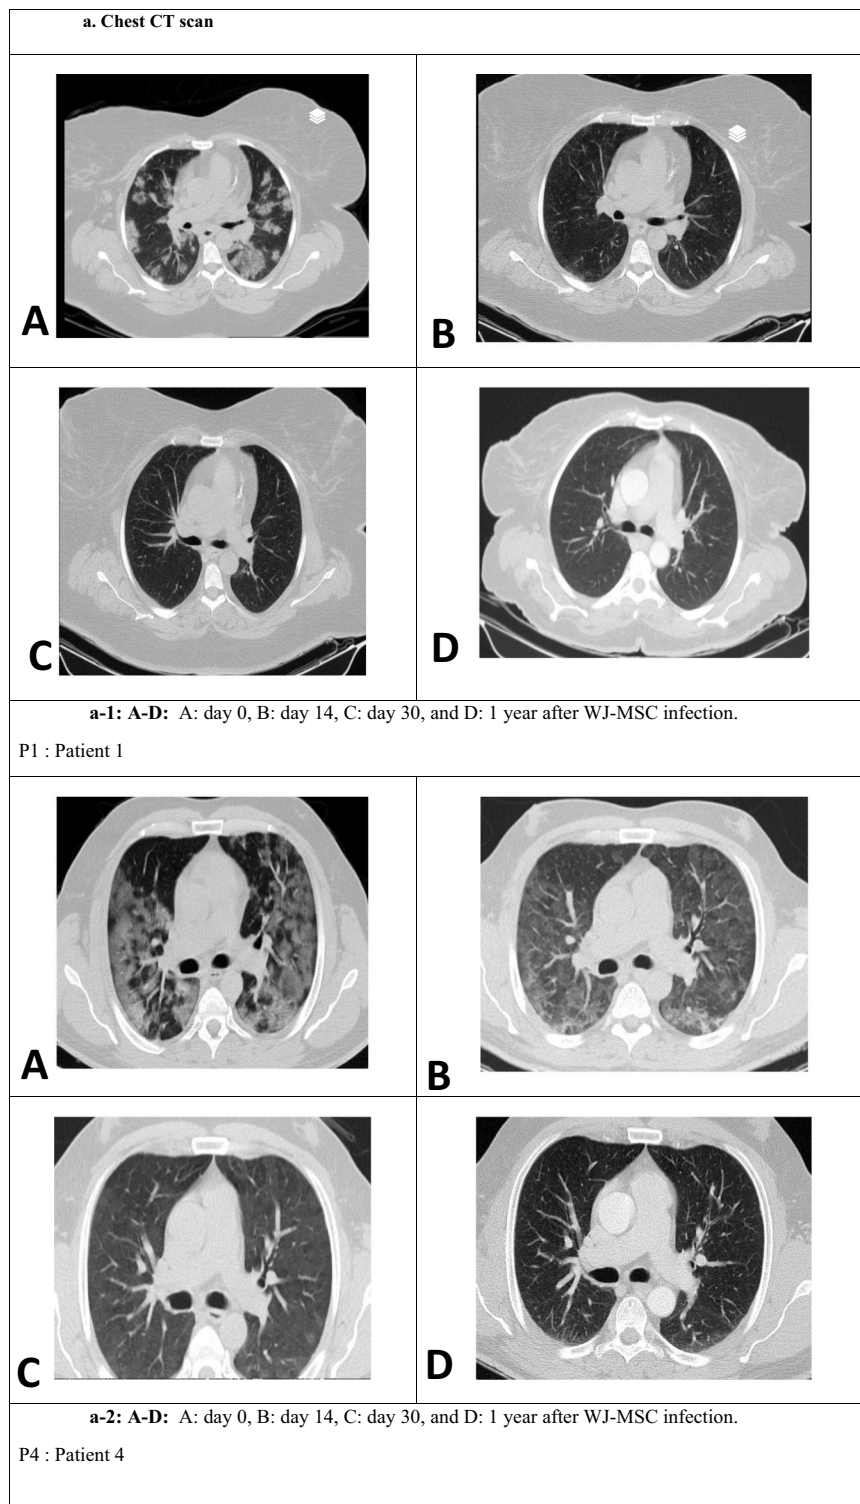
a. Chest CT scan.
